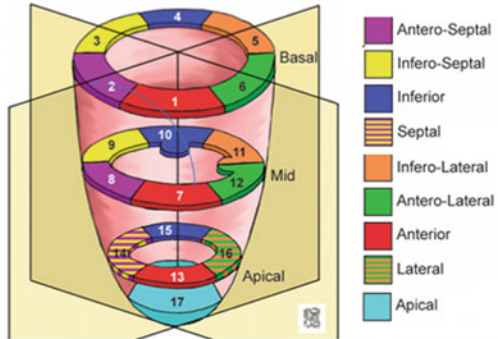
Left Ventricular Anatomy and Views. LV: Left Ventricle; EDD: End Diastolic Diameter; ESD: End Systolic Diameter; MV: Mitral Valve; MR: Mitral Regurgitation; LA: Left Atrium; AV: Aortic Valve; LVOT: Left Ventricular Outflow Tract; S': S' Doppler Wave; GL: Global Longitudinal; ME: Mid-Esophageal; TG: Trans Gastric; 4C: Four Chambers; 2C: Two Chambers; SAX: Short Axis; LAX: Long Axis; 5C: Five Chambers
